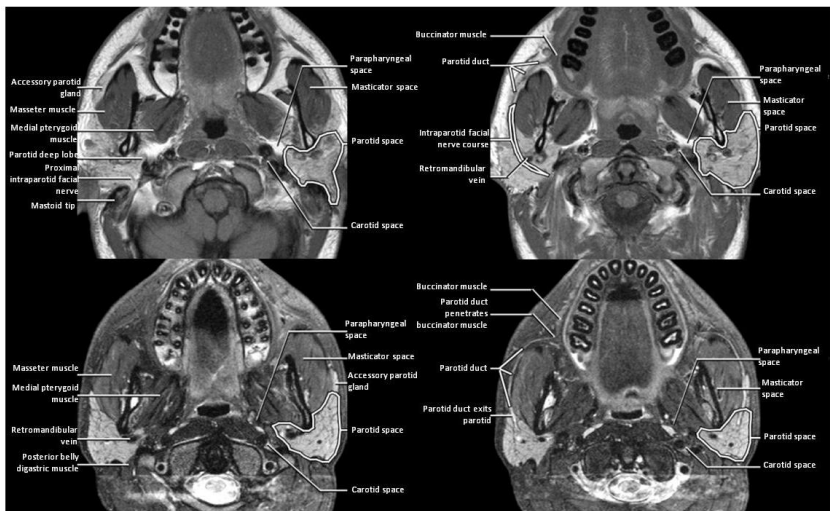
Example of MR T1-wighted (top row) and MR T2-weighted (bottom row) scan of the parotid region, at different axial planes. Figure from Amirsys reference centers.
